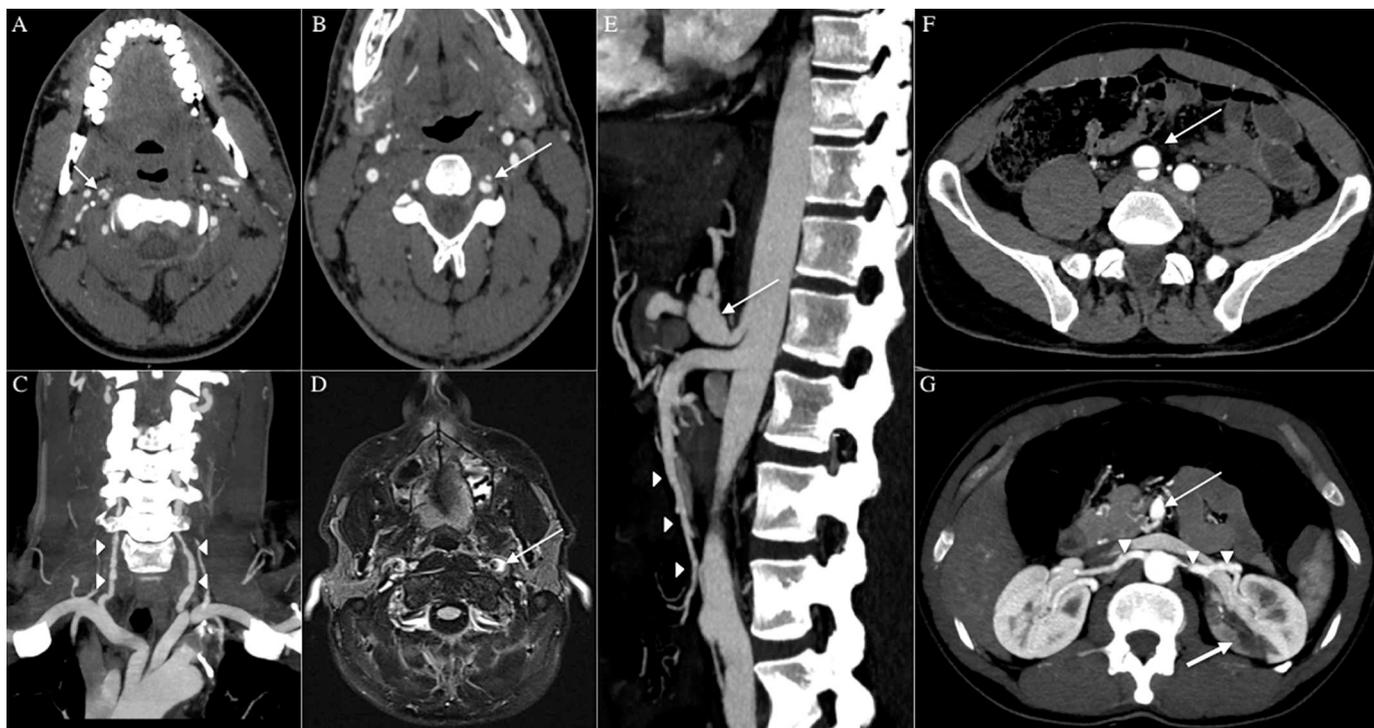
Imaging of the supra aortic trunks, intracranial and abdominal vessels. CT angiography of the supra-aortic trunks revealed dissecting aneurysms involving multiple arterial segments especially the right carotid artery (A, arrow), the left vertebral artery (B, arrow), the right vertebral artery (not shown) associated with multiple areas of stenoses involving especially the vertebral arteries (C, arrowheads). Brain MRI with axial spin echo FLAIR-Weighted sequence with fat suppression showed the left extracranial internal carotid artery intramural hematoma corresponding to a recent dissection (D, arrow).
